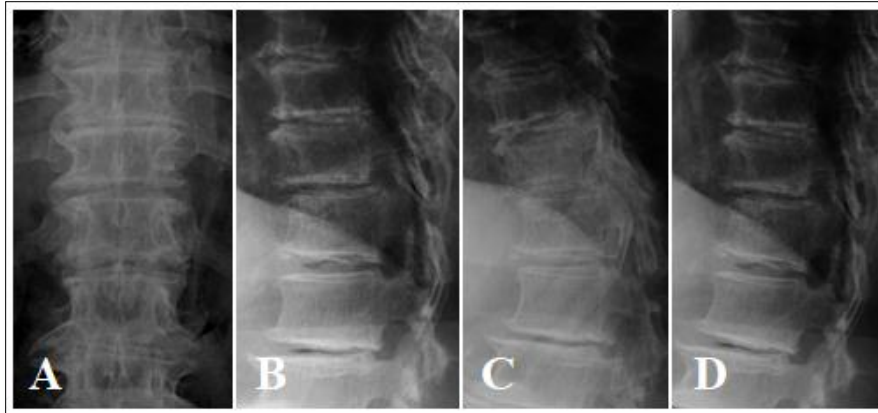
Grade I degenerative spondylolisthesis between T11 and T12 is observed on frontal (A) and lateral (B) plane radiographs. The pedicle-facet joint angles are 99°, 124° and 97° at T10, T11 and T12. Spondylolisthesis is 8 mm in the flexion position (C) and 5 mm in the extension position (D). The disc angle is 2° in the flexion position (C) and 0° in the extension position (D).
